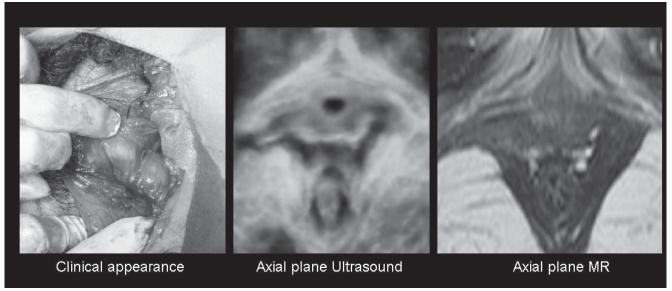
Delivery-related levator trauma as seen on exploration of a large vaginal tear after vaginal delivery (left), as imaged on translabial 4D ultrasound (middle) and on MR (right).
